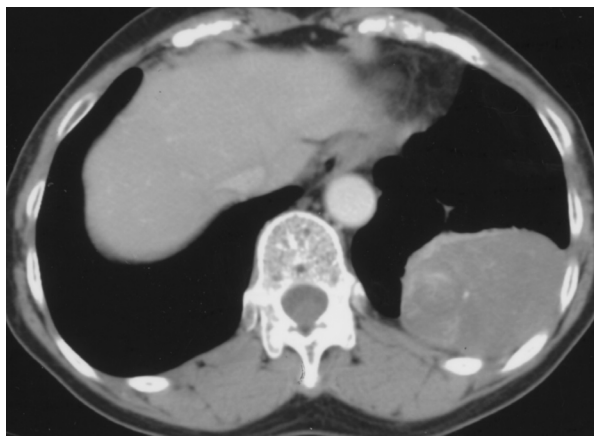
CT scan of the chest revealing a soft tissue mass with a heterogenous component in the left lower lung field.
